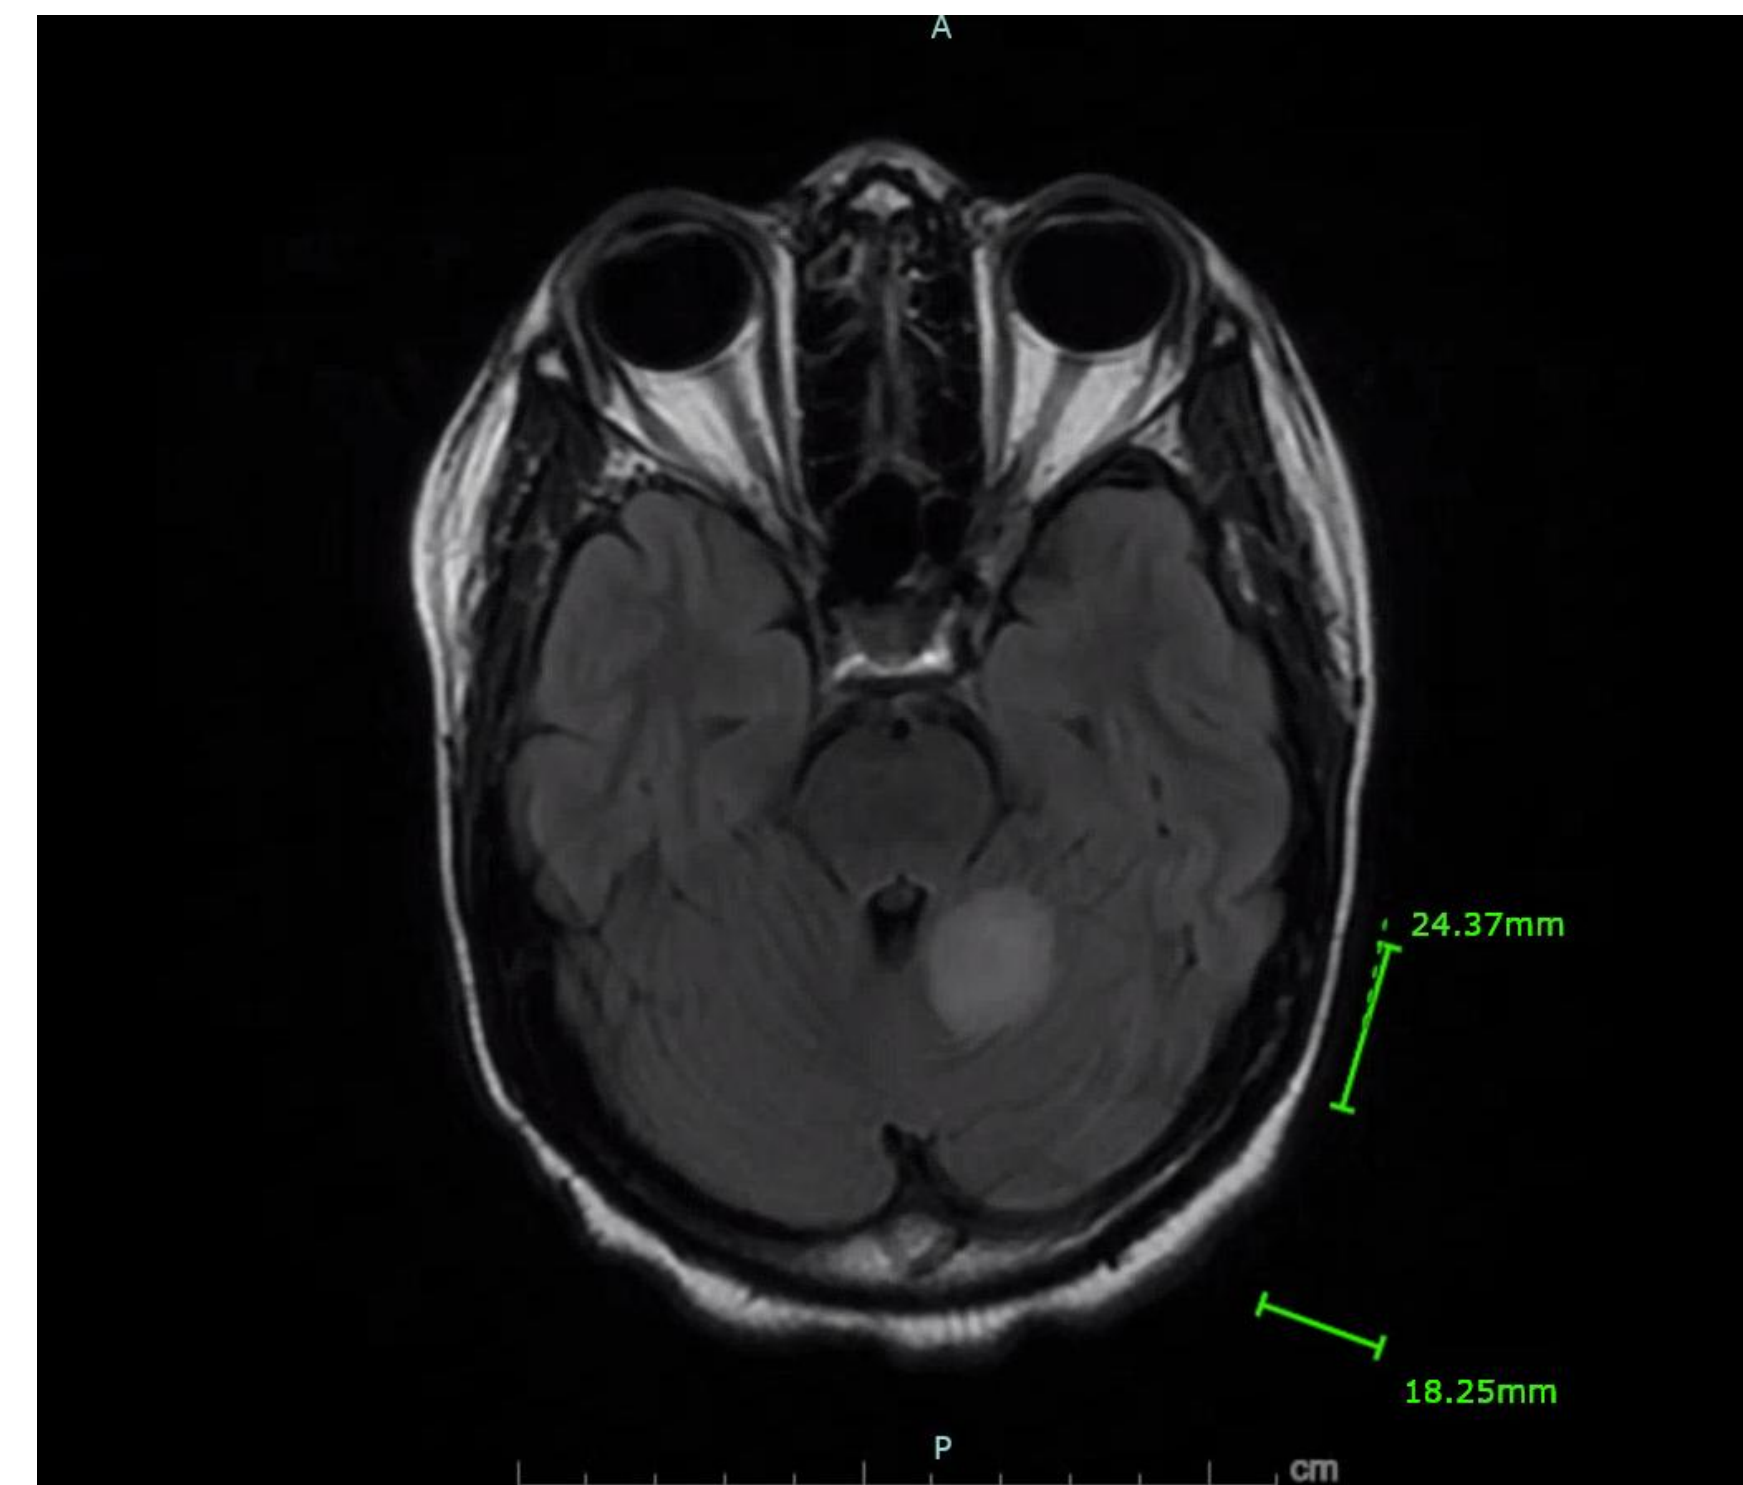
MRI Brain wo contrast, T2 FLAIR prior to treatment
